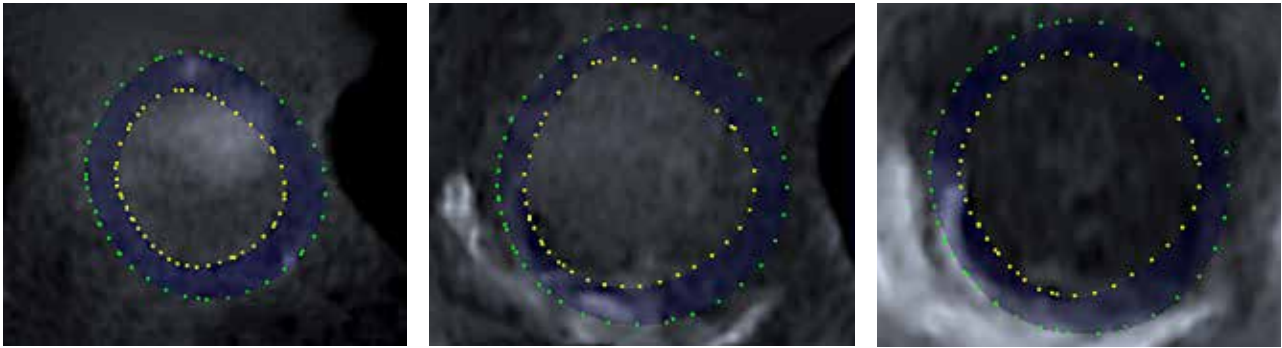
Short-axis views at different levels of the left ventricle extracted from the three-dimensional echocardiographic dataset.
